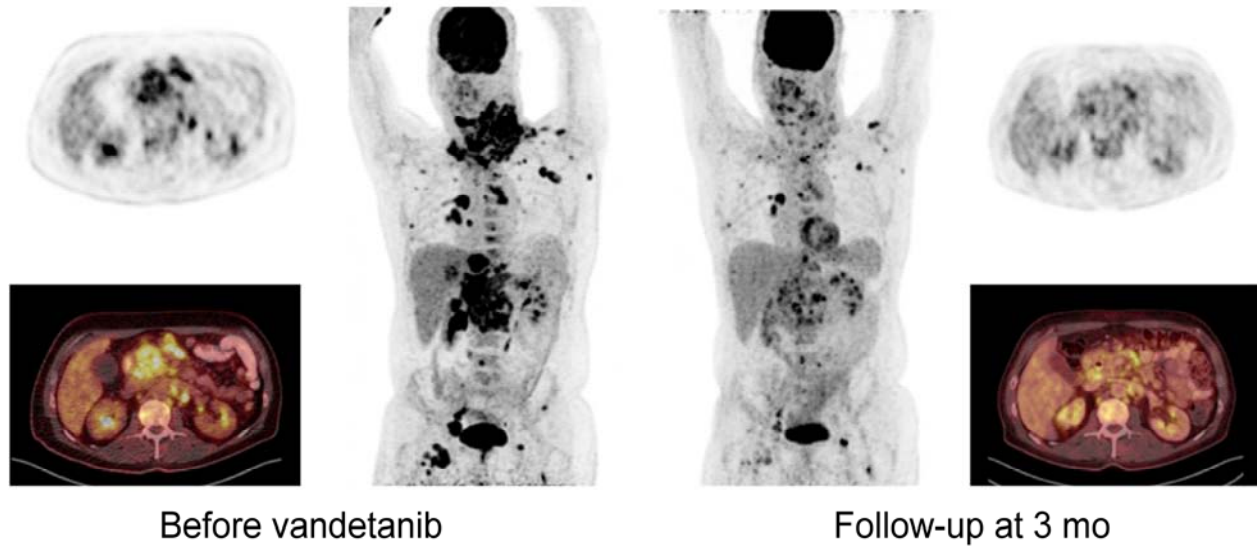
Example of a 47-year-old male with extensive tumor load (patient #12). Prior to tyrosine kinase inhibitor initiation the patient presented with highly aggressive disease with an mean standardized uptake value (SUV_{mean}) of the hottest lesion (right clavicular lymph node) of 13.4. After 3 months of vandetanib, a partial response could be detected with a decline of metabolic activity of 54.5% ($SUV_{mean} = 6.1$). However, due to disease aggressiveness, the patient died 11 months after start of treatment.
